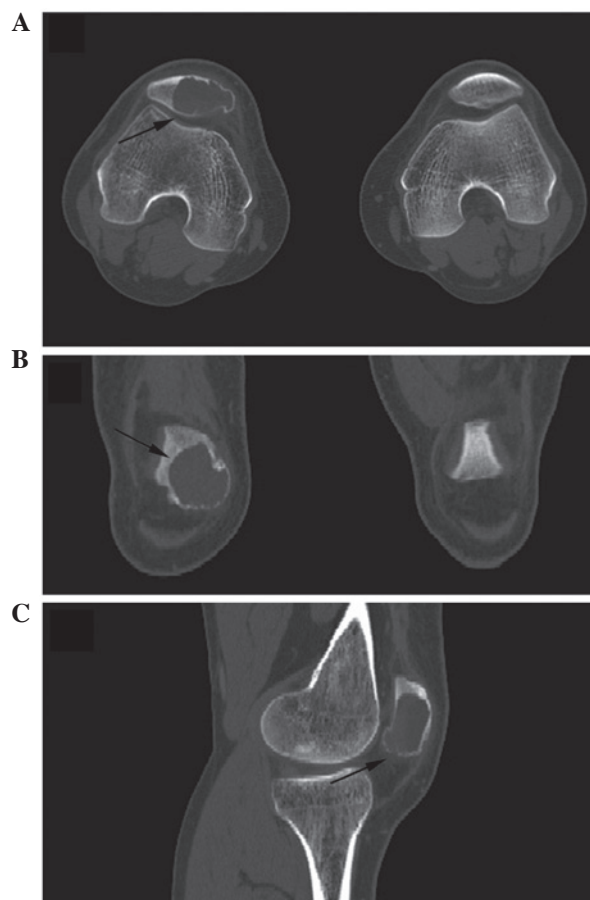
Preoperative computed tomography scan. (A) Axial, (B) coronal and (C) sagittal images showing a well-defined lytic lesion (arrows) with a thin cortex occupying 2/3 of the patella.
